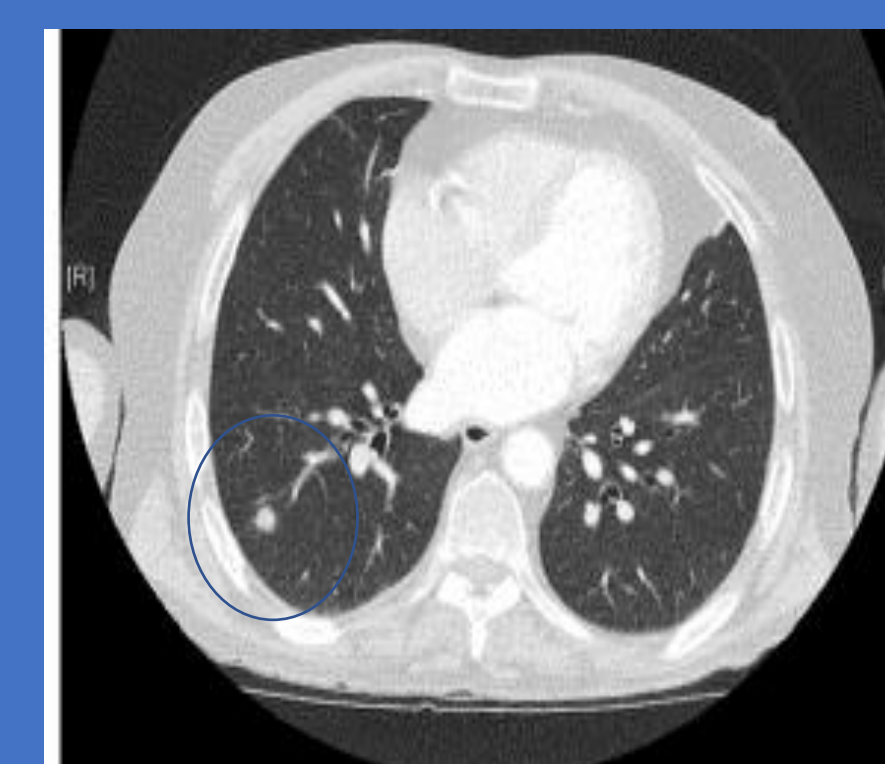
CT Scan showing Lung Metastasis (as circled)
